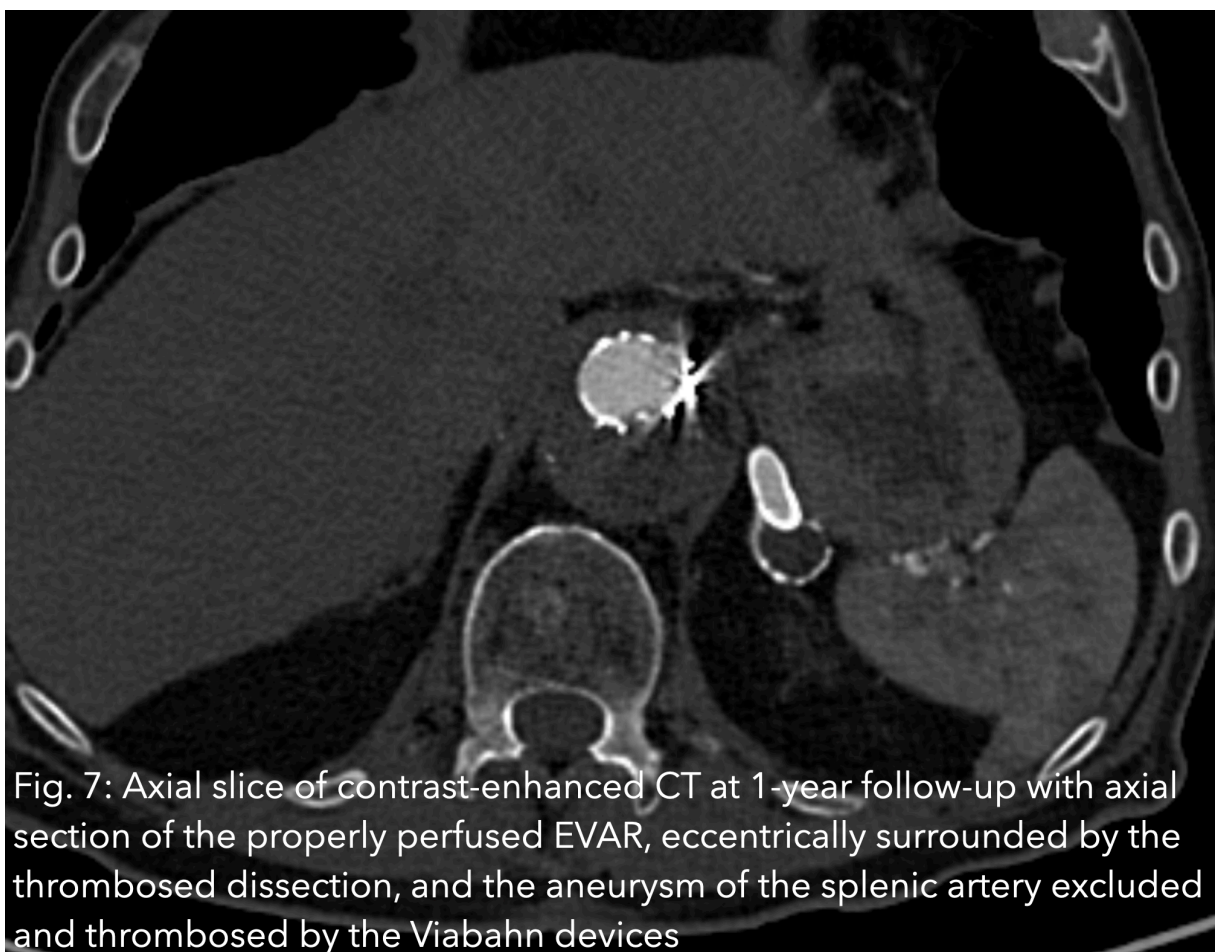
Axial slice of contrast-enhanced CT at 1-year follow-up with axial section of the properly perfused EVAR, eccentrically surrounded by the thrombosed dissection, and the aneurysm of the splenic artery excluded and thrombosed by the Viabahn devices
